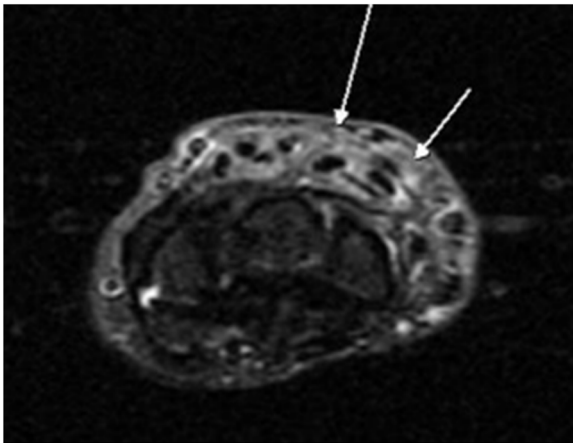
MRI of Left wrist. Arrows demonstrate the fluid collection to the extensor tendons.
